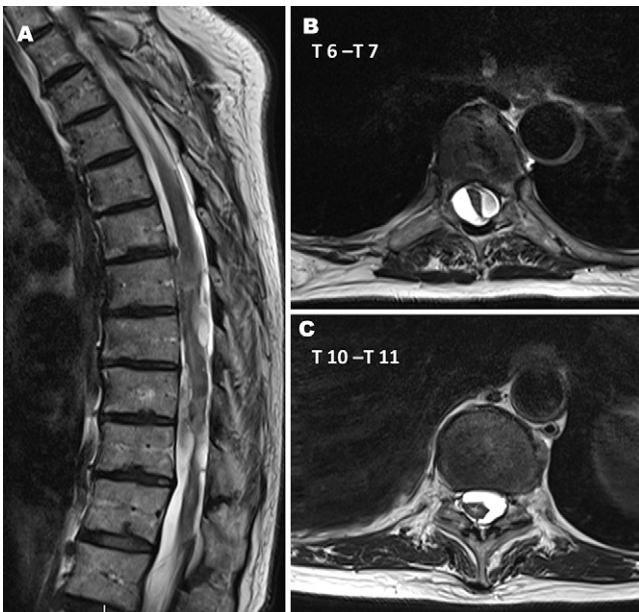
Postoperative MRI (A) at 3 months showing multilevel adhesive arachnoiditis from T6 to T11 with multiple arachnoid cysts. Flow void signal at the T6–7 level in the axial plane (B) and the T10–11 level (C) with severe radiological T2 changes.
